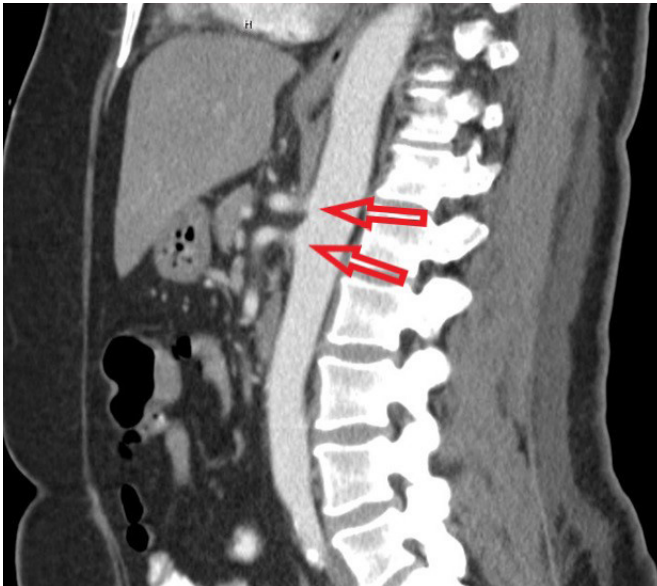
CT angiogram showing patent mesenteric vasculature.
